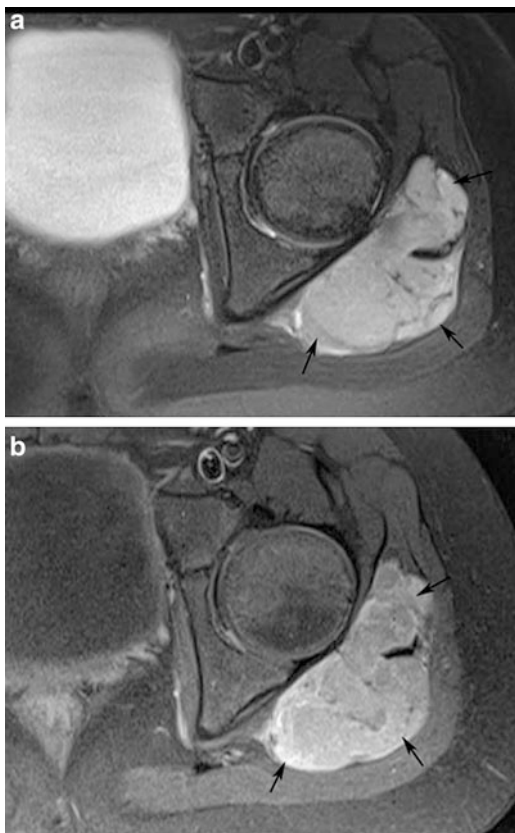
(a) Axial T2-FSE fs image in a 9-year-old male with left hip pain demonstrated a well-marginated lesion within the gluteal muscles (*black arrows*) with internal septations and bright signal intensity, concerning for complex cystic lesion versus solid mass. (b) Axial T1-weighted image with fat suppression after the administration of intravenous contrast demonstrated relatively homogeneous enhancement of the solid mass, which was later confirmed to represent a synovial sarcoma
